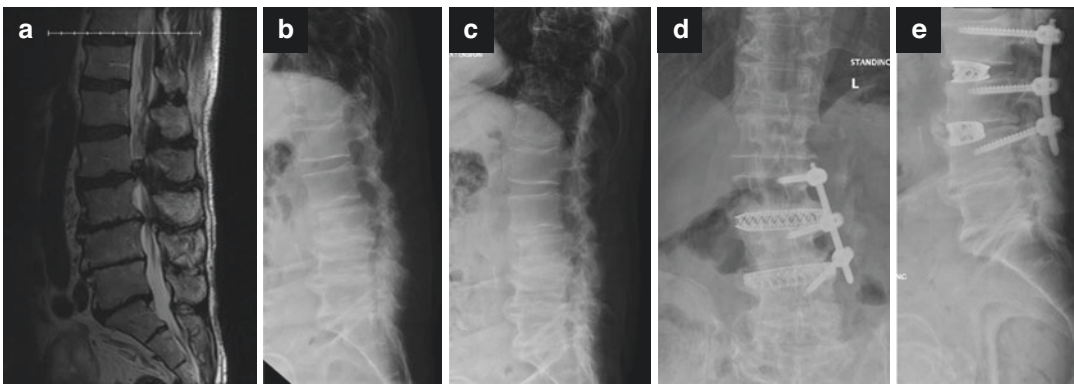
Preoperative T2-weighted MRI scan demonstrates degenerative changes throughout lumbar spine with stenosis most severe at L2–3 and L3–4 levels. Careful inspection of the L2–3 level on axial MRI (not pictured) and (a) sagittal MRI reveals fluid in the facet joints bilaterally, a synovial cyst on the left side, and severe stenosis.
